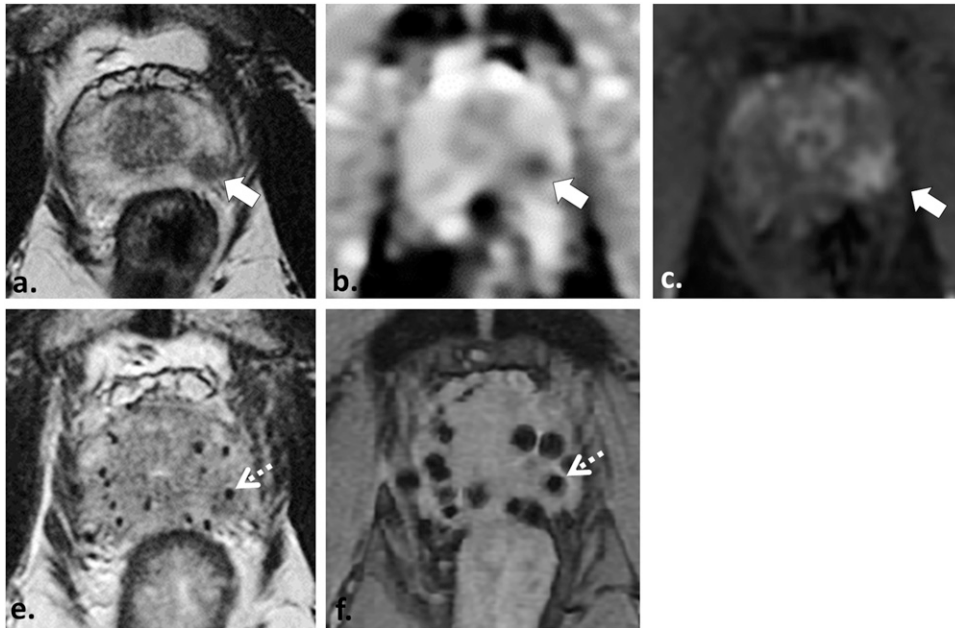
52 year old with Gleason score 3 + 4 = 7 tumour who underwent pre- and post-brachytherapy MRI (for local staging and post-brachytherapy treatment planning, respectively) demonstrates the challenge of tumour detection after implant insertion. Axial T_2 weighted (T2W) fast spin echo (a), axial apparent diffusion coefficient map (b) and axial image obtained from dynamic contrast-enhanced sequence (c) demonstrate a low T2W signal intensity focus in the left apical peripheral zone (white arrow in a) with corresponding restricted diffusion (white arrow in b) and focal hyperenhancement (white arrow in c) in keeping with the patient's known tumour in this location. Post-implant axial T2W turbo spin echo (e) and axial multiecho gradient recalled echo image (f) depicts multiple brachytherapy seeds which were inserted in the interim adequately covering the prostate gland and dominant tumour. Localization of the dominant tumour focus with MRI is nearly impossible after brachytherapy seed insertion; however, in this case, it can be inferred from pre-treatment MRI and is depicted by the dotted white arrows in (e) and (f).
